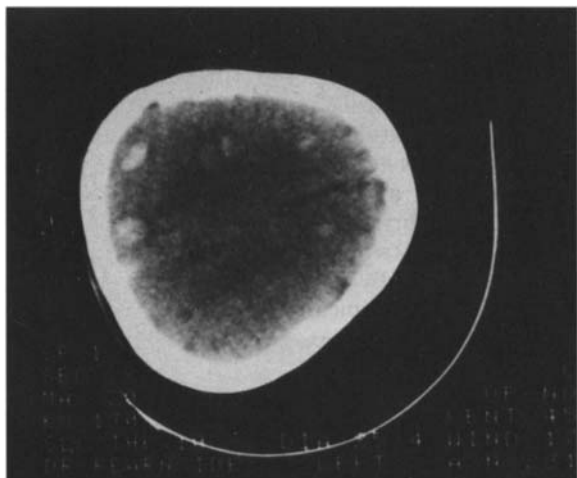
Pre-contrast CT scan of Patient 3 showing multiple small areas of high density consistent with hemorrhagic infarction.
